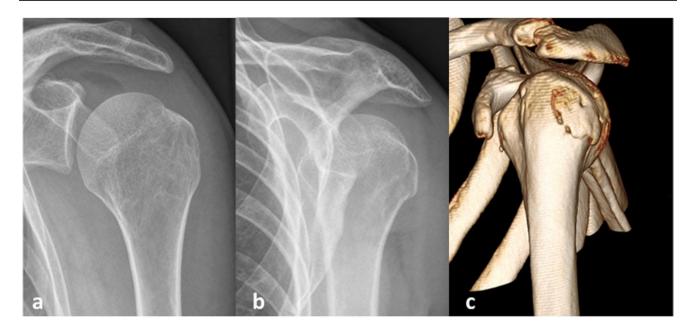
A 53-year-old teacher sustained an isolated, minimally displaced avulsion fracture (Mutch type 1) of the greater tuberosity after a fall. X-ray of the left shoulder in AP (\mathbf{a}) and scapular-Y (\mathbf{b}) views, and CT scan (\mathbf{c})
